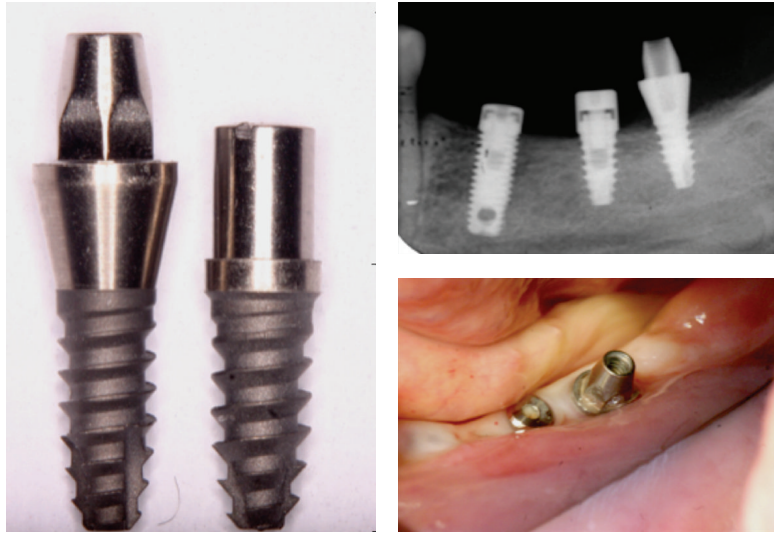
Clinical and radiographic view of the implants evaluated in the study.
